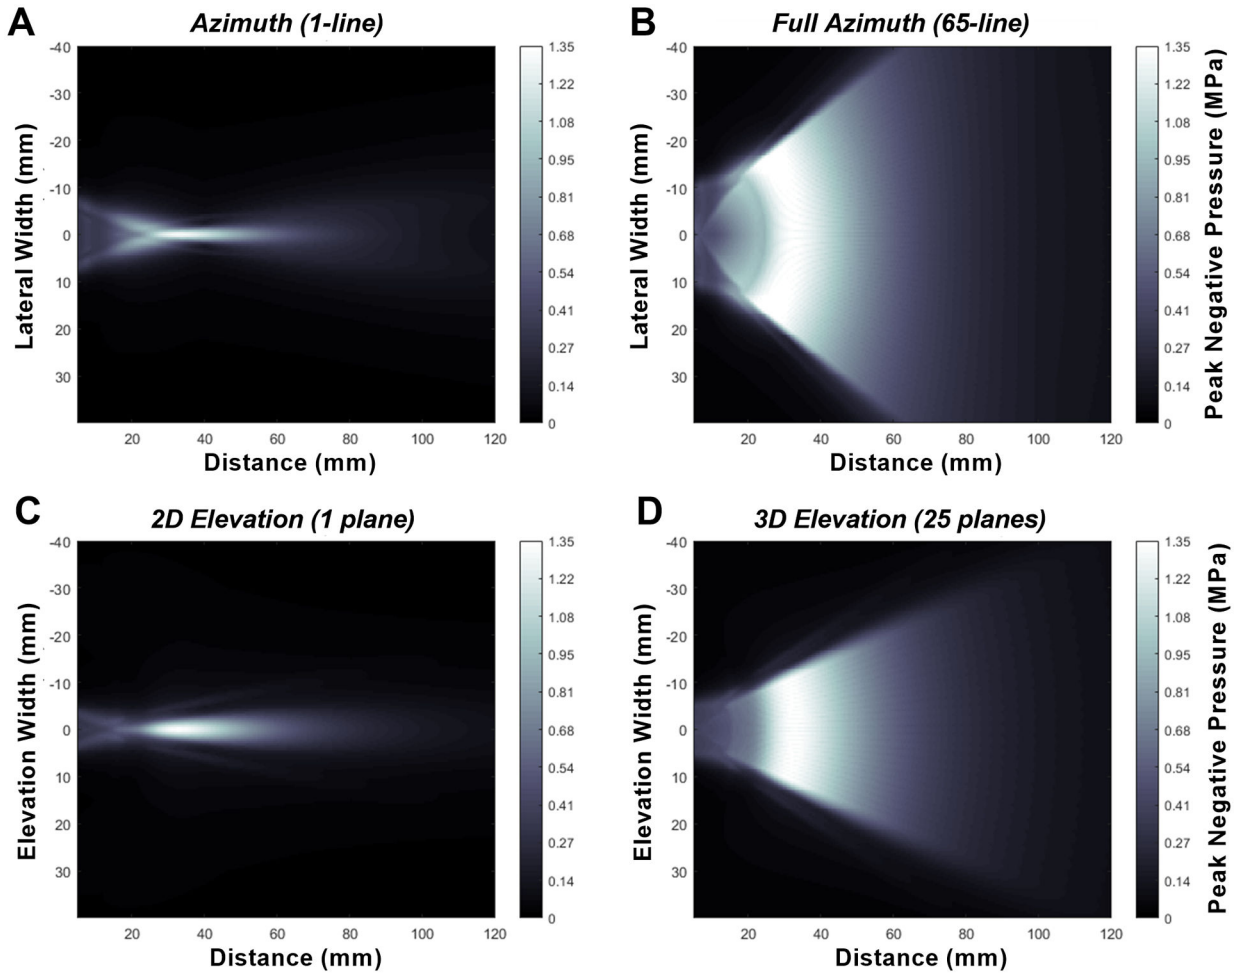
Visual display of ultrasound peak negative acoustic pressure with increasing distance (*x*-axis) from the ultrasound probe. For *y*-axis, dimensions are shown for (A) a single ultrasound line in the azimuthal dimension, (B) the full 65-line azimuthal profile, (C) the elevational dimension for the 2-D (1 elevational plane) transmission, and (D) the elevational dimension for the 3-D (25 elevational plane) transmission.
